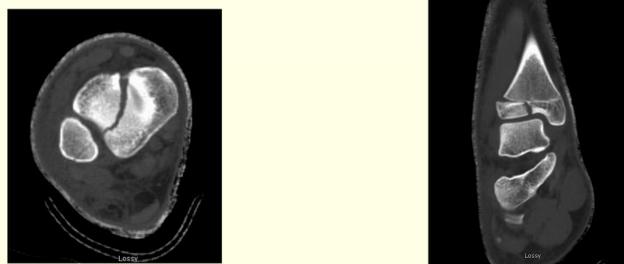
Figure 1AB Pre Op CT Scan demonstrating Tillaux fracture.
